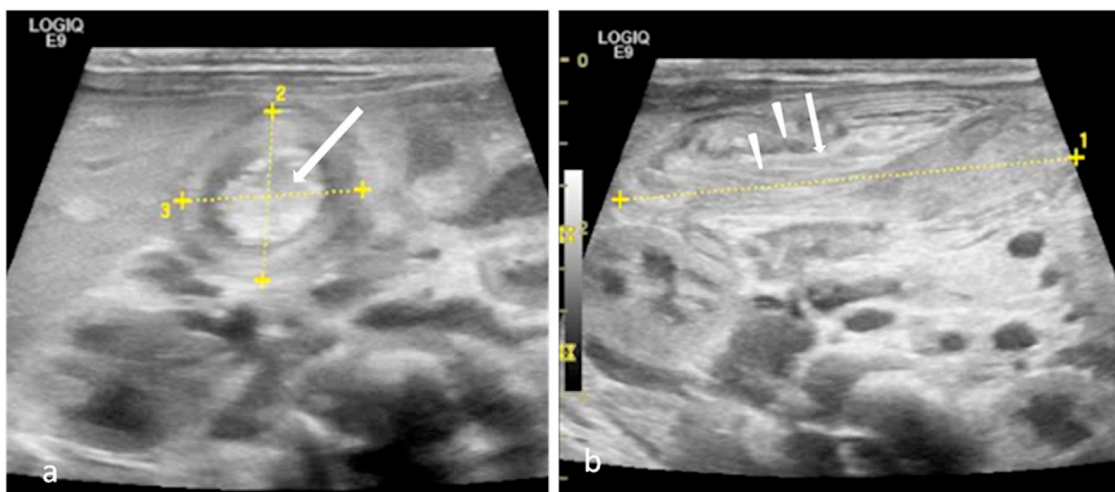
a: Ultrasound transverse view showing a target sign consisting of a peripheral hypoechoic ring with central echogenicity (white arrow) measuring 19 mm × 19.8 mm. b: Ultrasound longitudinal view showing a pseudo kidney sign consisting of a hyperechoic mesenteric fat (white arrow) contained between an external cecal wall and an internal ileal wall (white arrowheads) extending on 35.5 mm.
